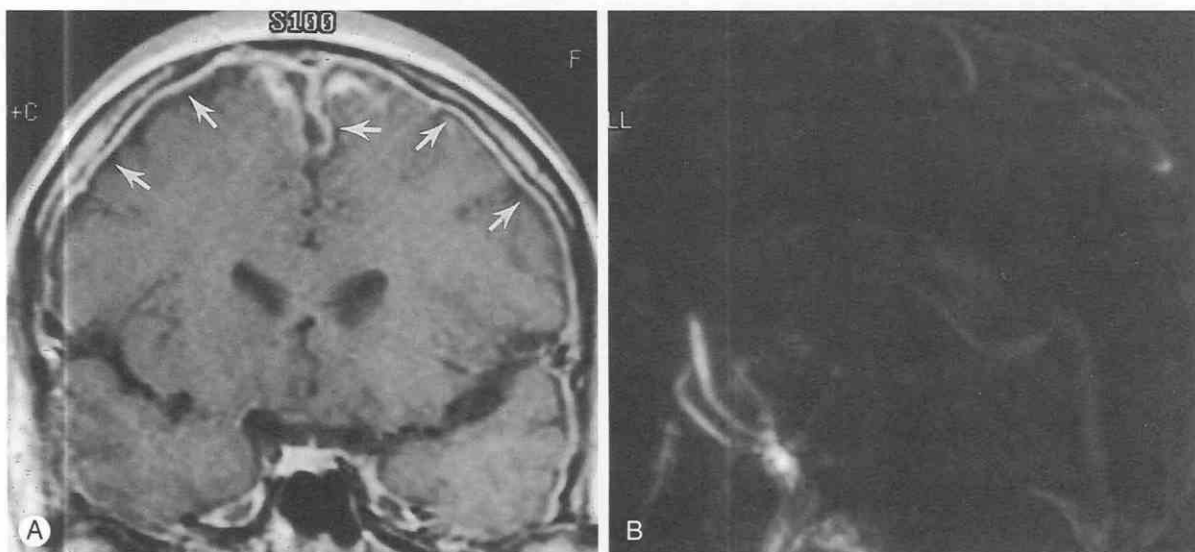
Diffuse dura/arachnoid enhancement. A, Coronal T1-weighted image shows dura/arachnoid enhancement (arrows) in a patient with meningitis and subsequent superior sagittal sinus thrombosis. B, There is an absence of flow in the superior sagittal sinus on a sagittal phase-contrast MR angiogram.
